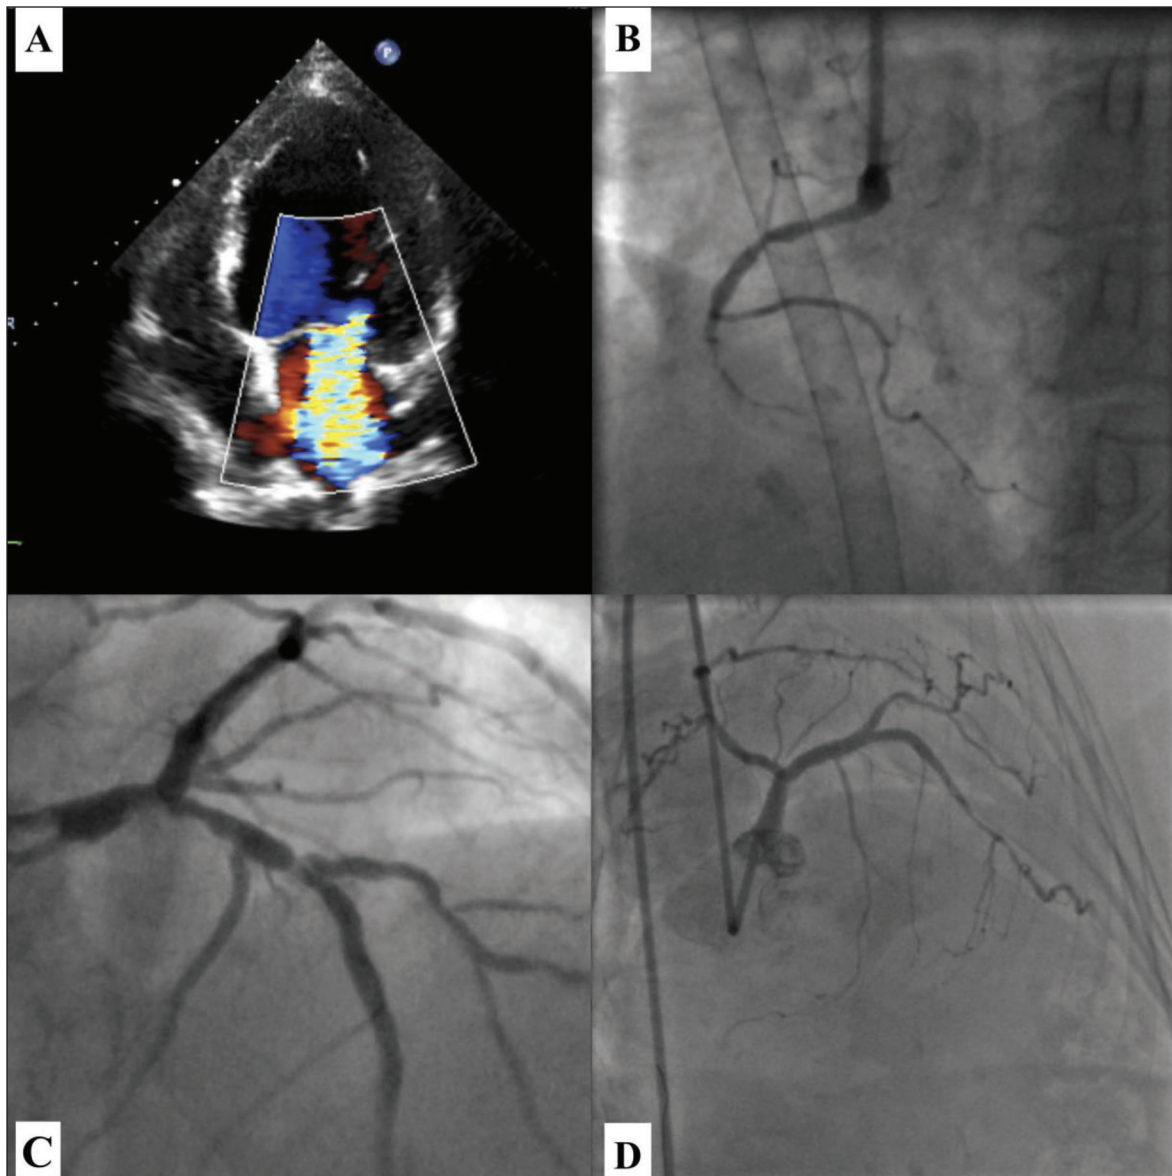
(A) Transthoracic echocardiography (TTE) showing severe mitral regurgitation. (B) Coronary angiography showing chronic total occlusion (CTO) of the right coronary artery (RCA). (C) Coronary angiography showing severe left main (LM) and left anterior descending artery (LAD) bifurcation (Medina Class: 1, 1, 0) stenosis prior to percutaneous coronary intervention. (D) Left main (LM) and left anterior descending artery (LAD) after successful implantation of drug-eluting stents (DES), the result of restored flow and final percutaneous coronary intervention (PCI). The spasm in the mid-LAD is visible
